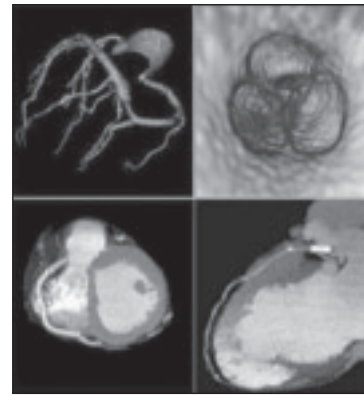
The advent of faster and more powerful multidetector CT scanners has made possible CT angiography (CTA) examination of the beating heart. However, capturing a dynamic organ in motion generates not just a single high-resolution
